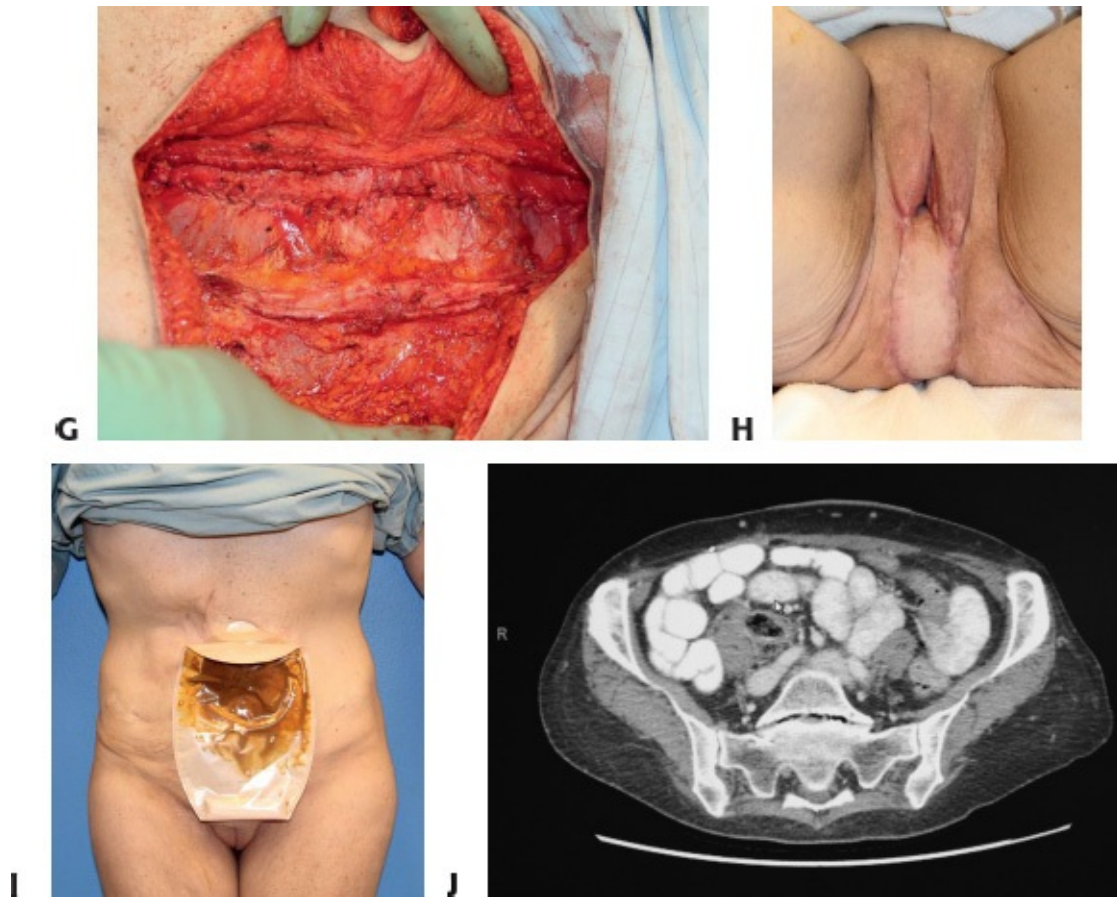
• Pelvic reconstruction and donor-site management. A. A 47-year-old woman with invasive cervical cancer required a total pelvic exenteration. B. Intraoperative defect. C. A pedicled vertical rectus abdominis muscle (VRAM) flap was elevated from the right hemiabdomen and passed through the pelvis (D) and inset for reconstruction of the perineum and posterior vaginal wall (E). F,G. Patient was thin with minimal abdominal wall laxity, and therefore a unilateral component separation was performed to facilitate closure of the VRAM donor site. H. This allowed for complete fascial closure. I. One year postoperative photo and J. CT scan.
